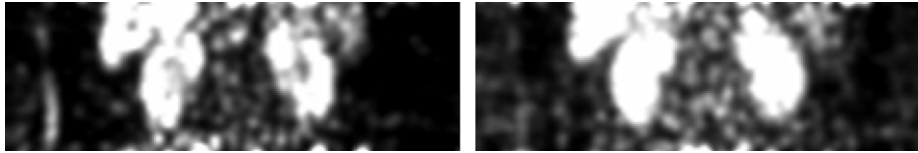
The kidney images in FDG-PET. On the left is a coronal section of one subject in this study at 3 min after injection, and on the right is the same coronal section of the same subject at 10 min after injection.
